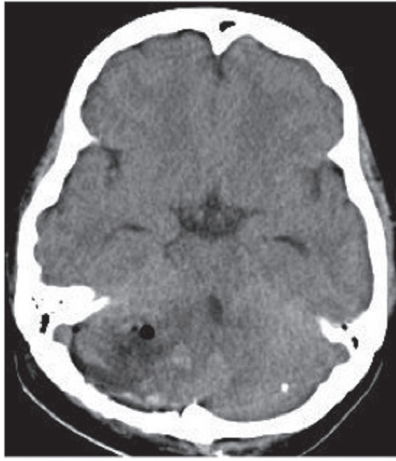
Postoperative computed tomography (CT) scan showing that the calcified tumor was totally removed.
